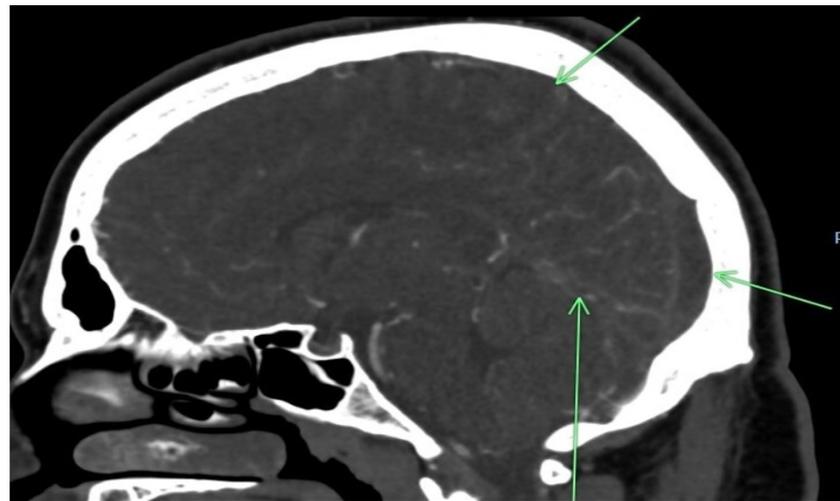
CT venogram showing filling defects throughout straight and superior sagittal sinuses (arrows), confirming cerebral venous sinus thrombosis.
